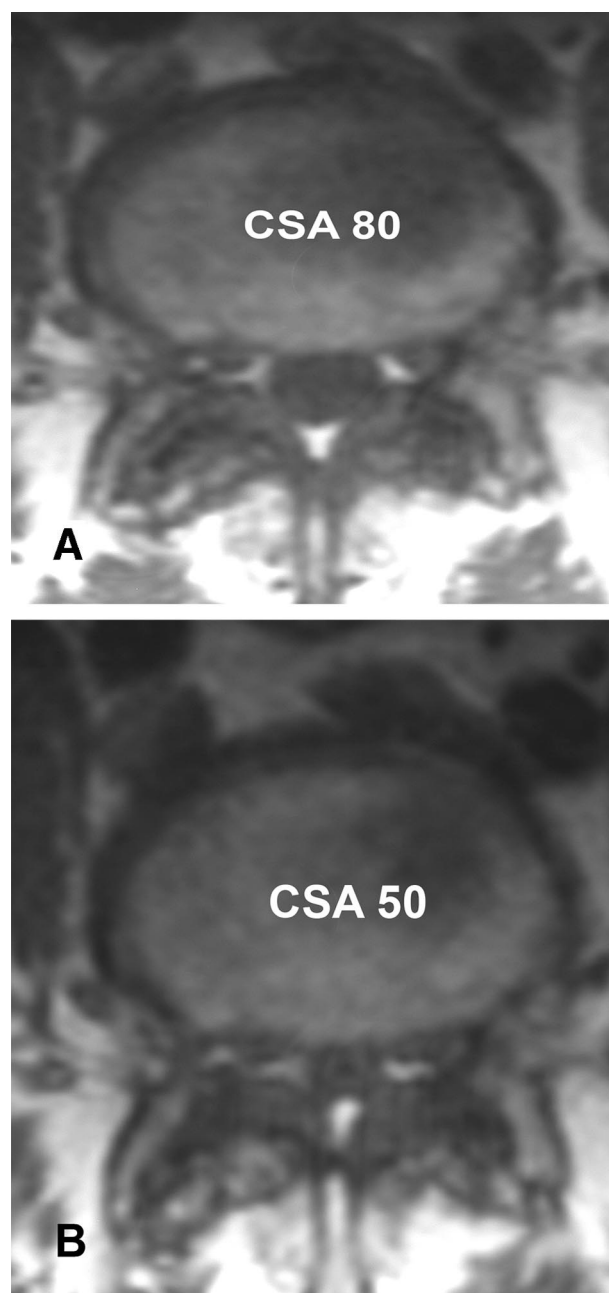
Patient MR14 (Tables 1 and 2). A 55-year-old woman with degenerative changes in L4–L5 level without obvious signs of spinal stenosis at MRI in unloaded position (A). She had bilateral neurogenic claudication, and walking capacity was below 200 m. At the loaded MRI examination (B) the dural sac cross sectional area decreased from 80 to 50 mm² and the L5 nerve roots were compressed in the lateral recesses. She was operated with decompression and posterolateral fusion in the L4–L5 level. At follow-up, 6 years later, her walking capacity was more than 1 km and she was pain free.
